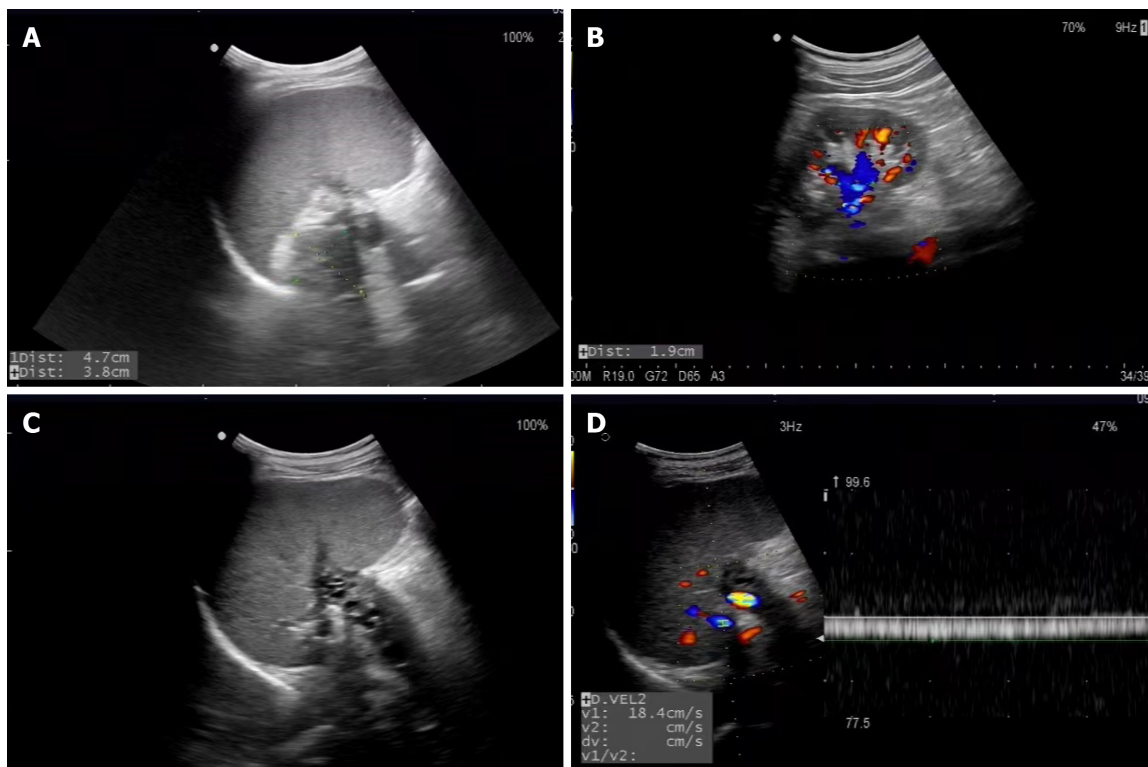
Ultrasonography imaging. A: Pancreatic pseudocysts with the cystic heterogeneous hypoechoic area; B: Renal venous congestion; C: The formation of splenic venous collateral and main splenic venous thrombus; D: The peak velocity of splenic venous collateral with continuous waveform.
